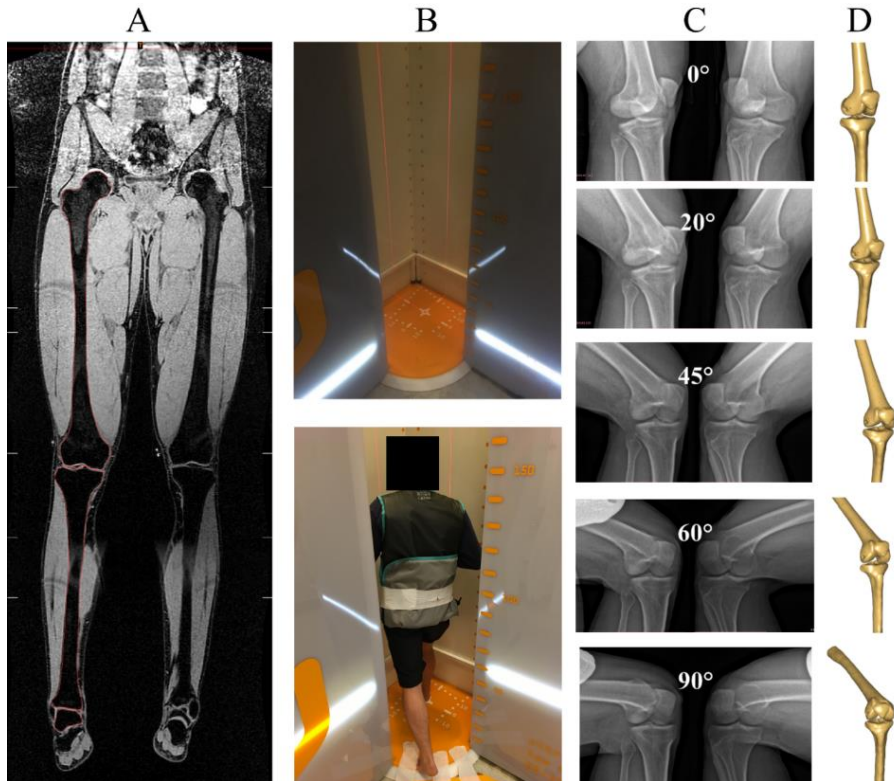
A method of combining MR and EOS Imaging technology: A, Development of 3D knee geometry using a stack of coronal MR images; B, and acquisition of quasi-static lunge (lower image) using two orthogonally positioned low dose x-rays (top image). C, Bi-planar EOS images were taken at roughly 0°, 20°, 45°, 60°, and 90° tibiofemoral flexion. D, Bone positions were determined by combining the 3D knee model with the bi-planar contours and applying optimization methods.
